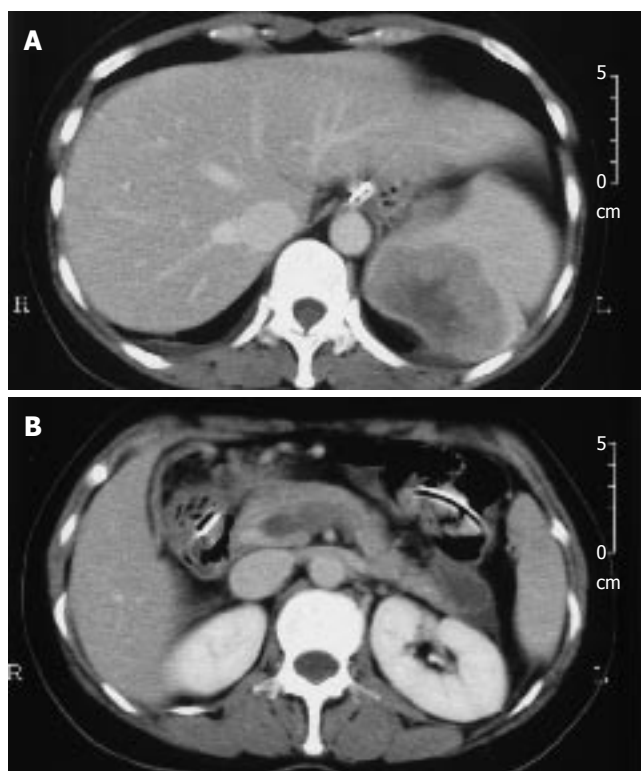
Contrast-enhanced computed tomography of the abdomen. A: Enlarged spleen with hypodense lesion in the superior spleen which was considered to be splenic metastasis; B: Hypoattenuating thrombus in the splenic vein and the portal vein.
